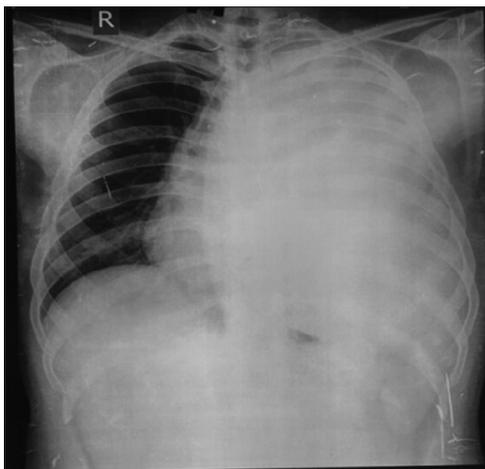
Chest radiograph showing homogeneous opacification of left lung field
